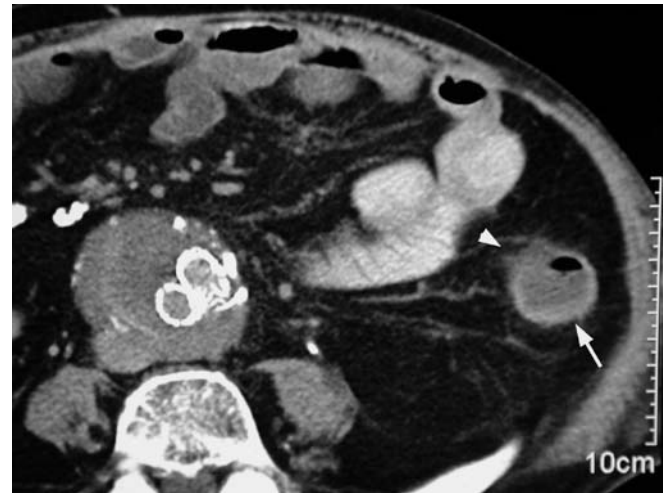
Ischemic colitis of the descending colon following aortoiliac stent implantation. CT shows mild wall thickening of the descending colon (*arrow*) with minimal paracolic stranding (*arrowhead*)—a finding that might be missed in contracted colonic segments
